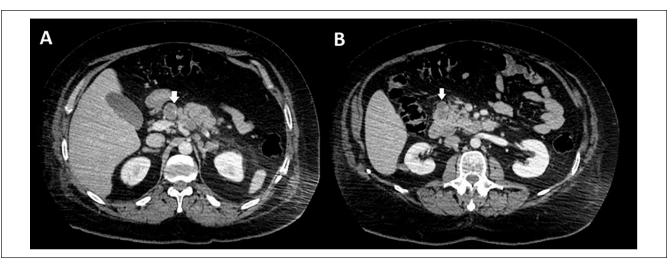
Computed Tomography of abdomen with contrast, initial. (A) Peripancreatic lymph node, measuring 2.6 cm \times 2.0 cm. (B) III-defined area of low attenuation in the pancreatic uncinate process measuring 2.3 cm \times 1.9 cm.
